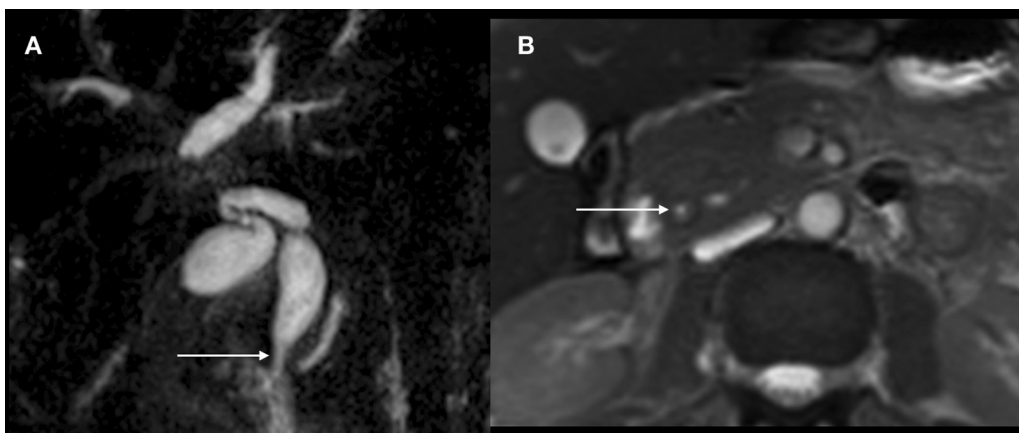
Young male with jaundice, known human immunodeficiency virus (HIV) positive. Coronal three-dimensional (3D) magnetic resonance cholangiopancreatography (MRCP) thin slab image (A) showing narrowing at the lower end of the common bile duct (CBD) (arrow) with dilatation of the intrahepatic biliary radicle dilatation consistent with HIV cholangiopathy. Axial T2-weighted (T2W) images (B) showing circumferential thickening of lower end of the CBD.
